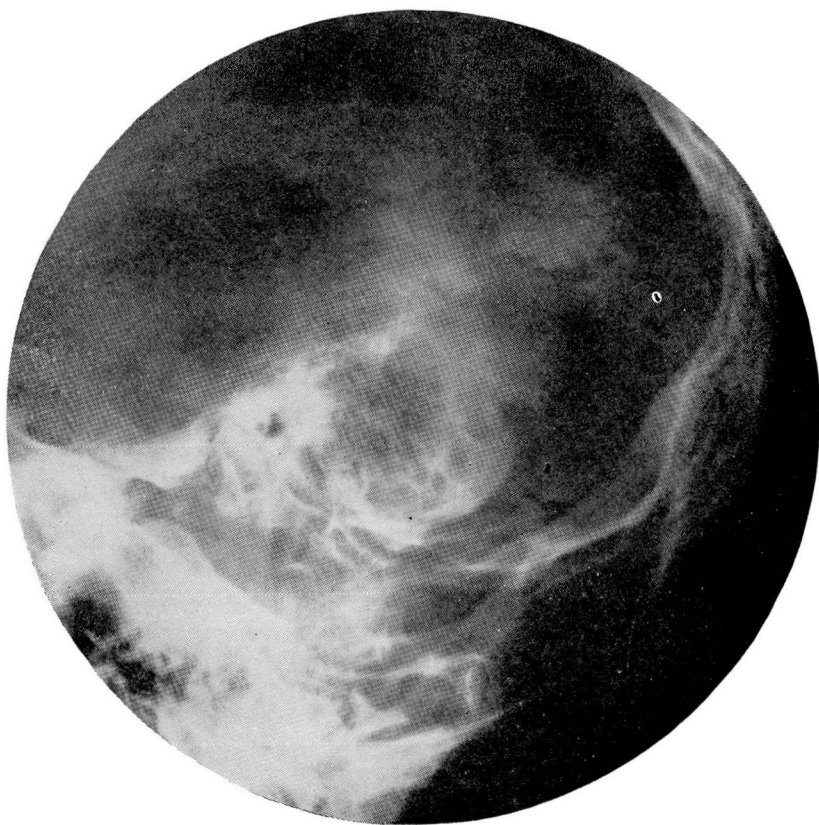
(Case 1): Roentgenogram of right mastoid.
